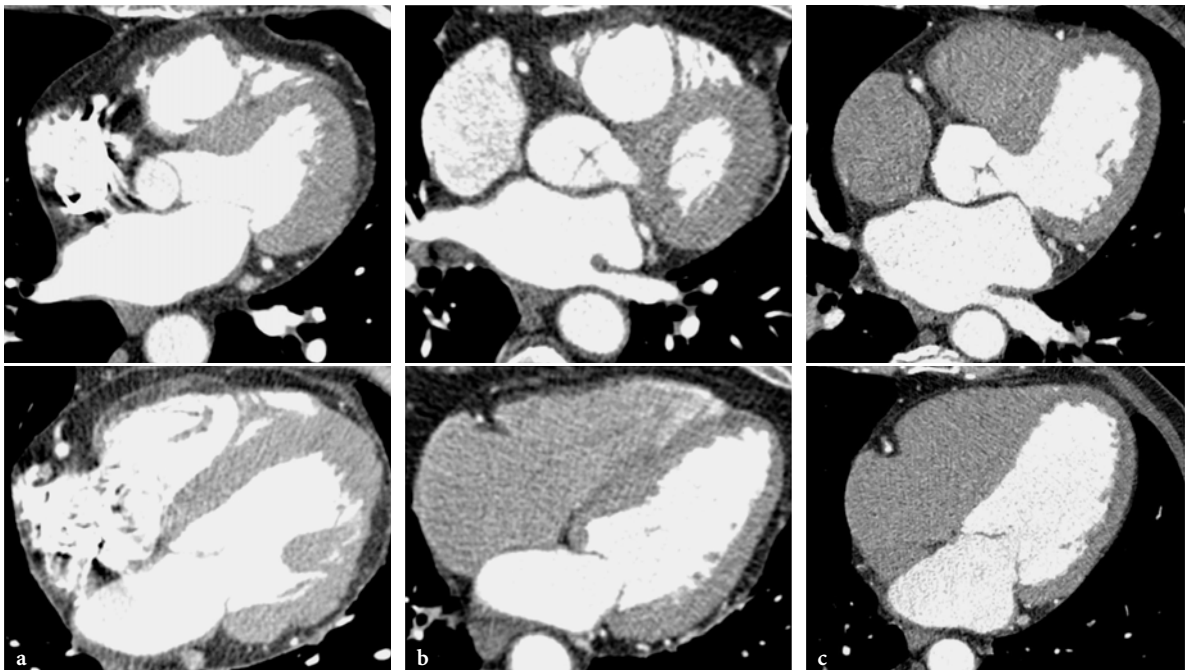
The scan time and therefore the amount of contrast media necessary can be reduced from 4-slice CT (a), to 16-slice CT (b), to 64-slice CT (c). With dedicated timing, selective enhancement of the left ventricle is possible with just 80 ml of contrast media
